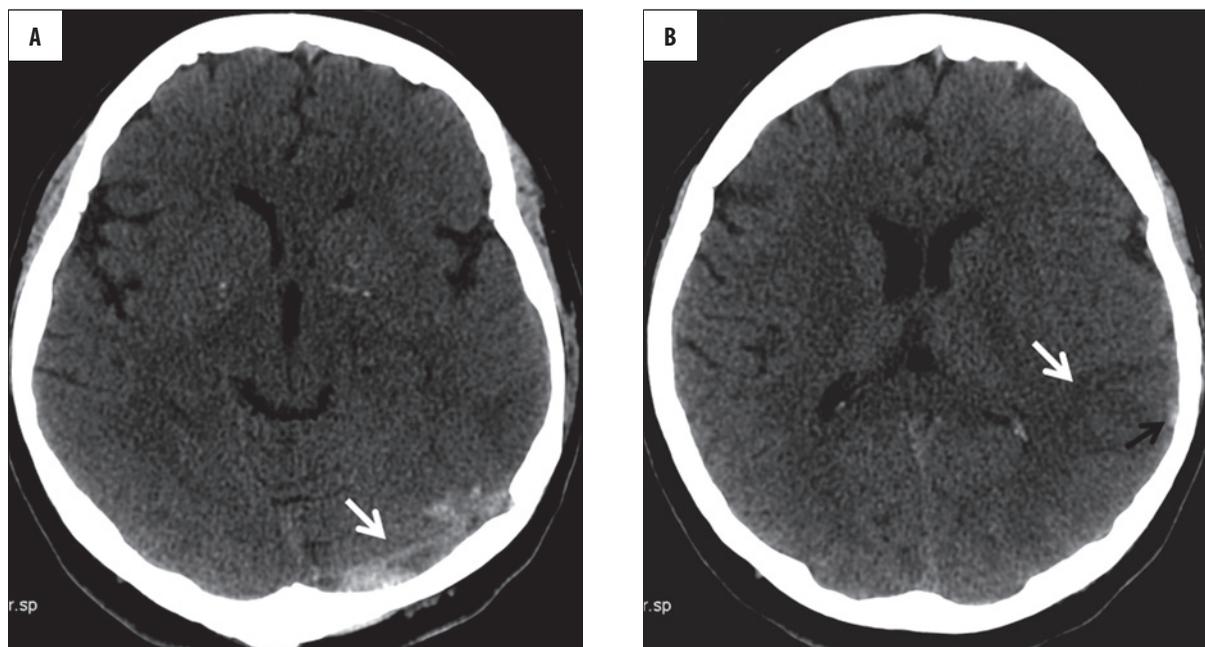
Patient with an infarction due to cerebral venous thrombosis. Emergency non-contrast CT scans. (A) – thrombosed, hyperdense left transverse sinus (arrow), (B) – hypodense venous infarction within the left temporal cortex (white arrow) and thrombosed hyperdense vein of Labbe (black arrow).
